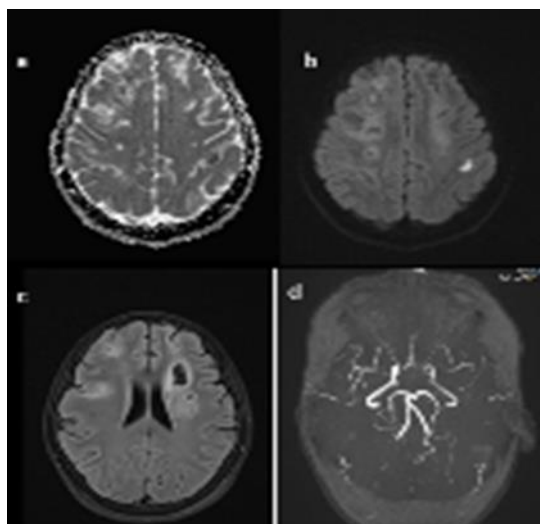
Cerebral MRI showed recent ischemic lesions in the territories of the right and left superficial sylvian arteries visible in diffusion hypersignal (b) with ADC restriction (a) and old sequelae visible in FLAIR sequence. The TOF sequence (d) showed slowed flow in the M1 segments of both right and left middle cerebral arteries.
